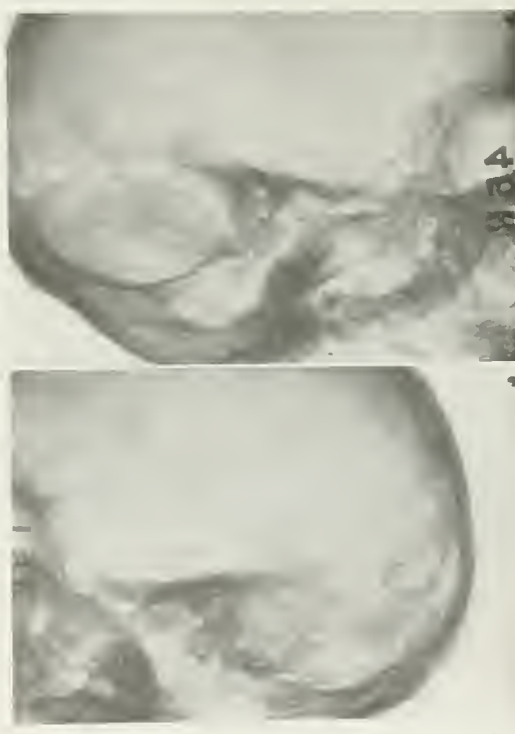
Left Eye Image. Roentgenograms of dried skull. Right side above, left side below, punch marks at the right. Figures 1 and 2 can be stereoscoped in the ordinary Wheatstone stereoscope.
